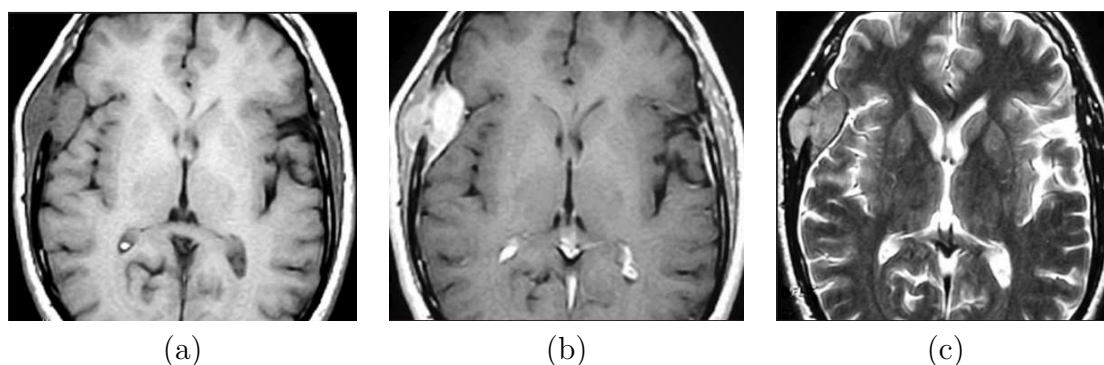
A full-enhanced tumor without edema. a) Axial slice of T1-weighted image. b) The same slice of contrast enhanced T1-weighted image. c) T2-weighted image.
